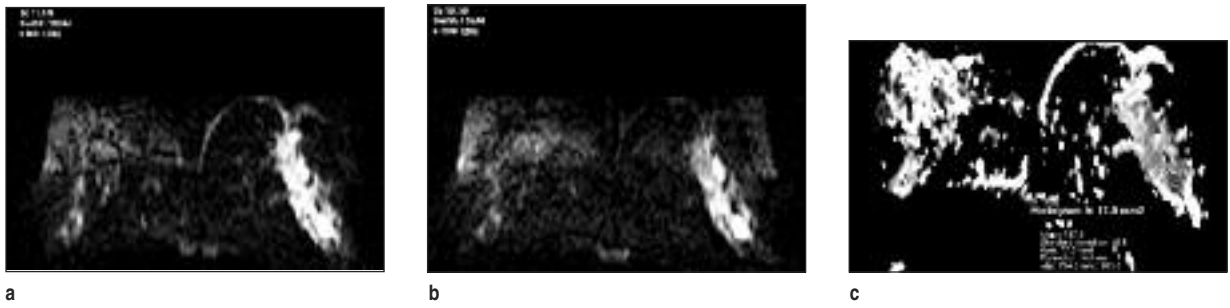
Diffusion weighted MRI of the same patient in Figures 7 and 9 with diffusion sensitivities as a. $b=500\text{s/mm}^2$ and b. $b=1000\text{s/mm}^2$ images demonstrate high signal intensity due to restricted diffusion. Note that the highest signal is obtained from the abscess cavity. c. ADC mapping demonstrates low signal intensity of the IGM lesion. ADC value of the abscess is very low, measured as $797 \times 10^{-6} \text{ mm}^2/\text{s}$.
